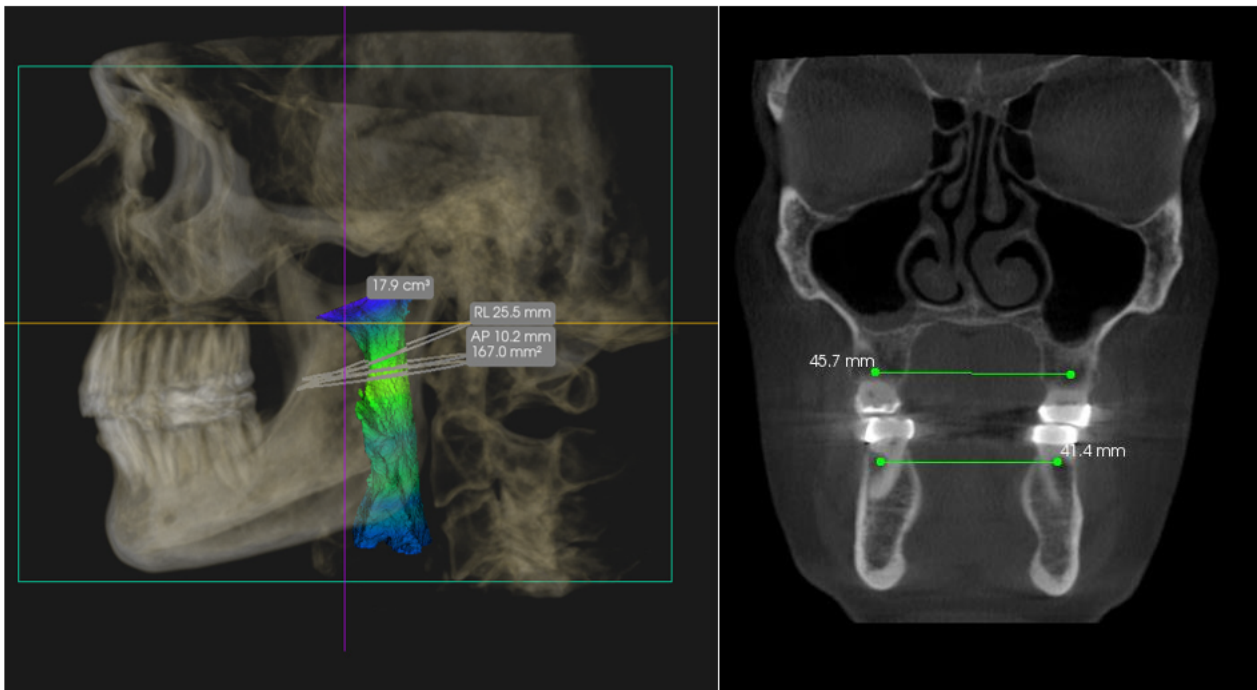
series c: CBCT shows a minimal axial airway of 167 mm² and well-coordinated maxillary and mandibular transverse widths.
